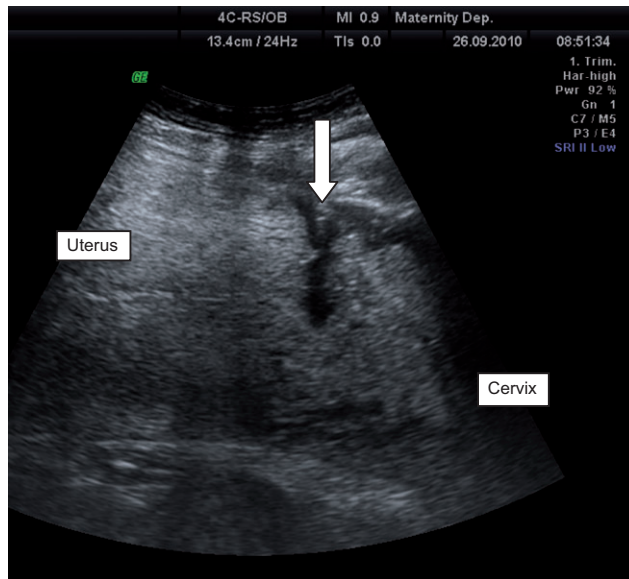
Two-dimensional ultrasound of the uterus demonstrating a hypoechoic area at the lower uterine segment (arrow), representing bleeding through uterine rupture into the abdomen.
